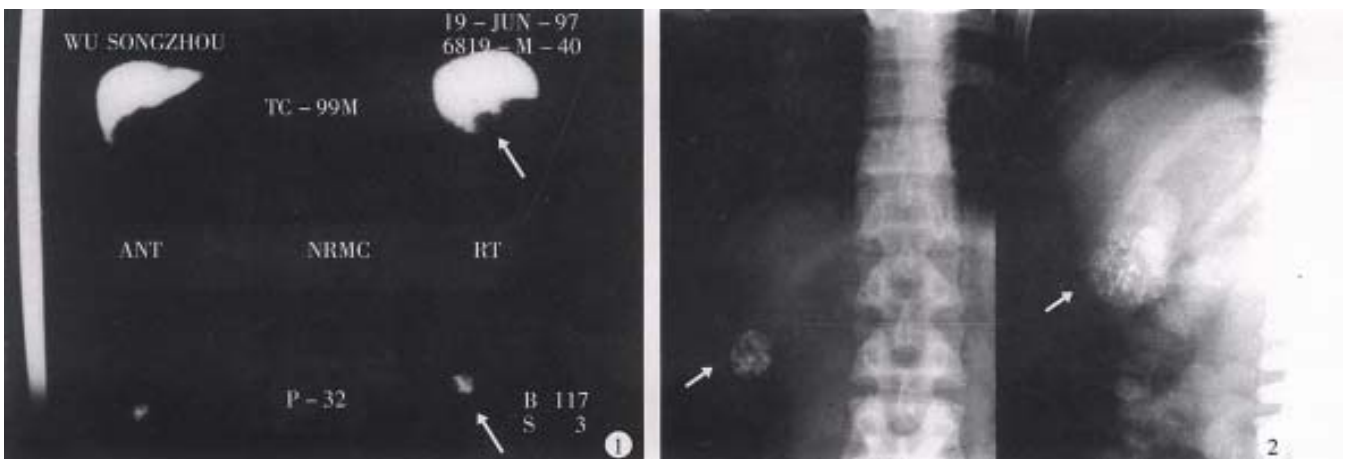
Male, aged 41, hospital no.207089, clinical diagnosis: uremia, right hepatic small carcinoma (4cm×3cm), with AFP>400μg/L treated by regimen A for 2 courses with interval of 3 months, resulted in AFP restored to normal level and decreased tumor size over 50%. 1, Colloidal SPECT imaging showed the space occupying lesion in the right liver lobe (as shown by arrow). 2, Comparing the tumor size before and after treatment of plain film (as arrow shown), the patient died from renal failure 26 months after operation.
